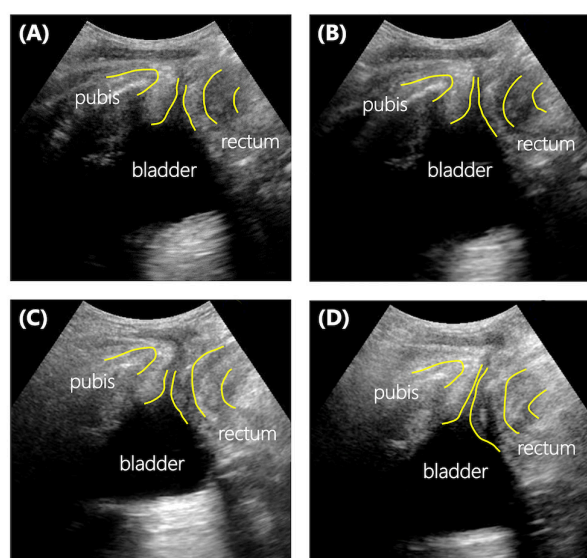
Transperineal ultrasound images of a patient who underwent RARP shows urethral closure in the midsagittal plane. First TPUS-guided PFMT (A) at rest and (B) during contraction of the pelvic floor muscle. Last TPUS-guided PFMT (C) at rest and (D) during contraction of the pelvic floor muscle. RARP, robot-assisted radical prostatectomy; TPUS, transperineal ultrasound; PFMT, pelvic floor muscle training.
